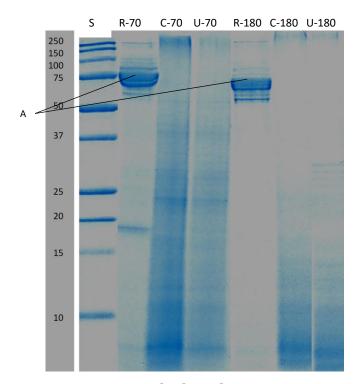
Tricine SDS-PAGE electrophoretogram showing protein profile of the digested pāua samples after 10 or 120 min of small-intestinal digestion. S, standard; R, raw control; C, cooked control (no pre-treatment prior to canning); U, cooked ultrasound pre-treated[#]; 70 and 180 are the digestion times (following 60 min gastric and 2 min oral digestion), in min. A, corresponds to a 75-79 kDa peptide.
